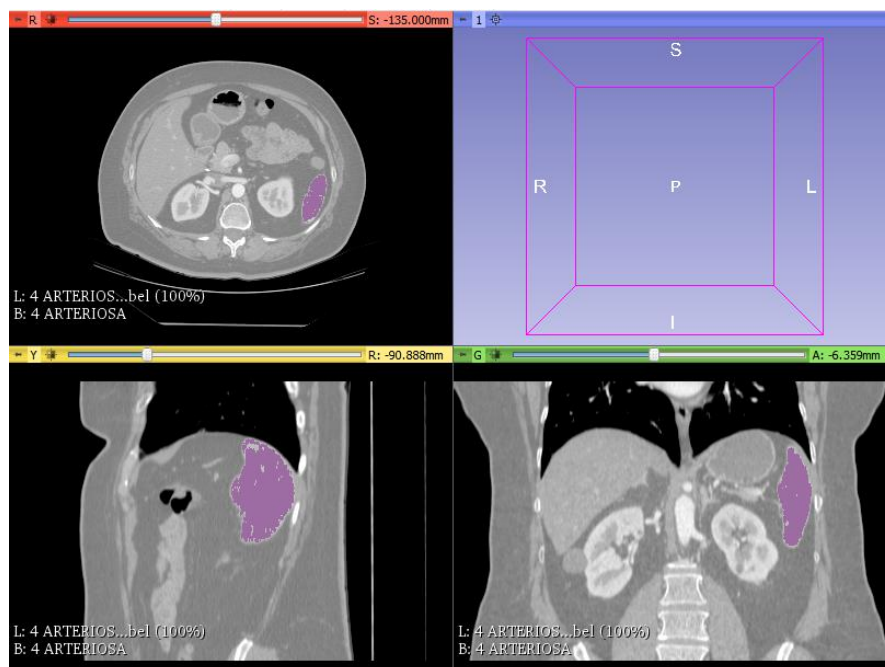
The segmentation phase of the spleen in an abdominal cavity CT
